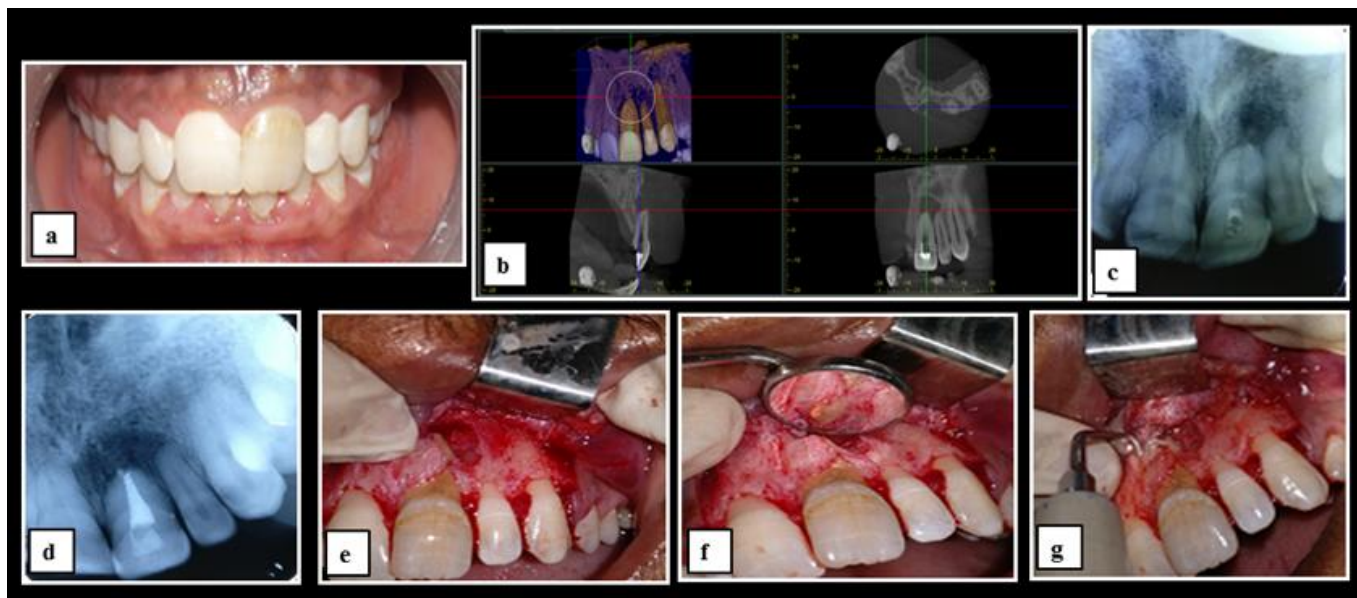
(a) Pre-operative clinical photograph, (b) Cone beam computed tomography (CBCT) evaluation, (c) Pre-operative Periapical radiograph of the left maxillary central incisor (#21) with apical radiolucency, (d) post-obturation radiograph, (e) Flap reflection and bony window prepared, (f) Root end resection, (g) Root end preparation in 21 followed by enucleation.
